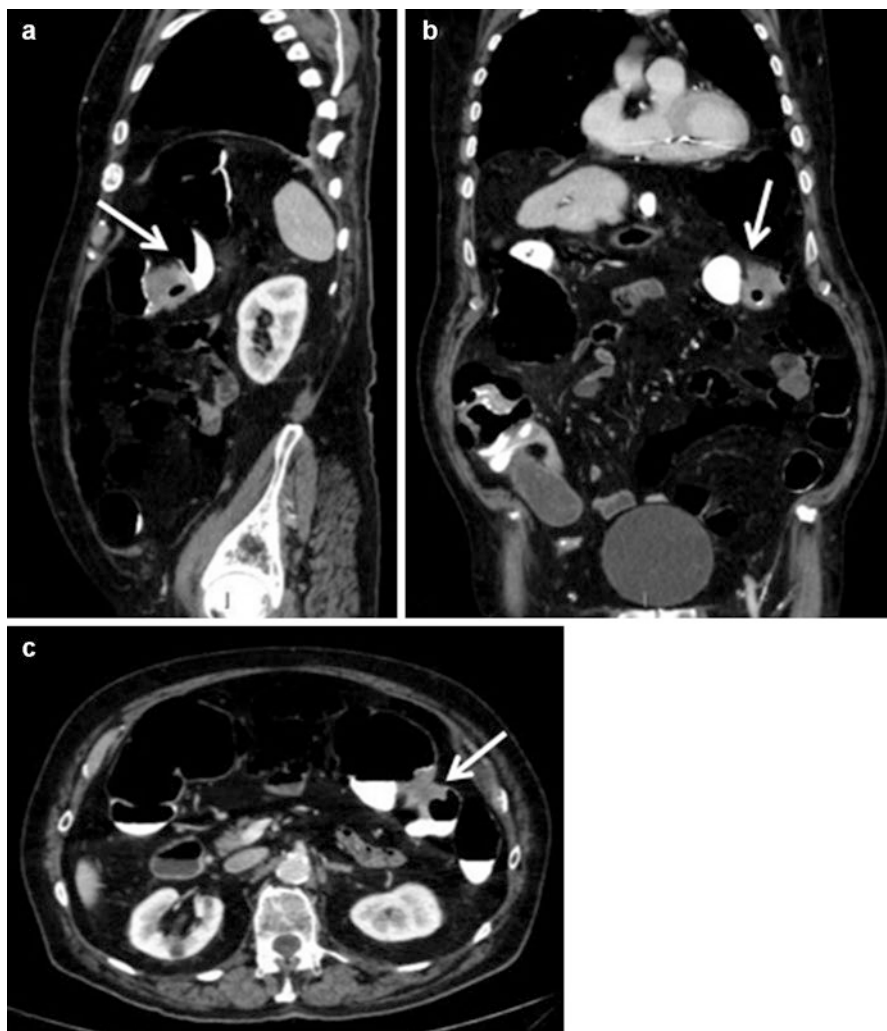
CT scan after administration of enteroclysis contrast: the neoplastic wall thickening determines the stop of the contrast immediately proximal to the stenosis localized at the splenic flexure (*white arrows, a–c*)
